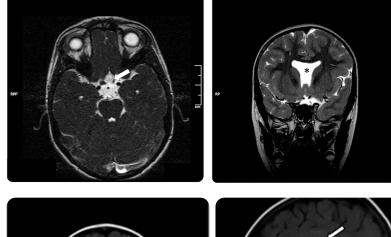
a and b) 6 months old male patient with diagnosis of convulsive syndrome. MRI axial slice 3D FIESTA-C: left optic nerve hypoplasia (arrow). MR coronal reconstruction T2 frFSE: agenesis of pellucid septum (*).
